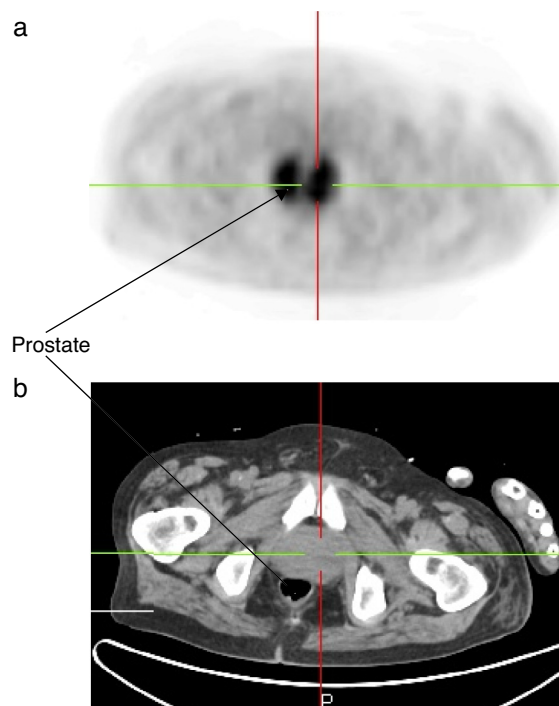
PET scan showing an intense and diffuse accumulation of the FDG in the prostate (A: PET imaging; B: scanned imaging of the prostate).
